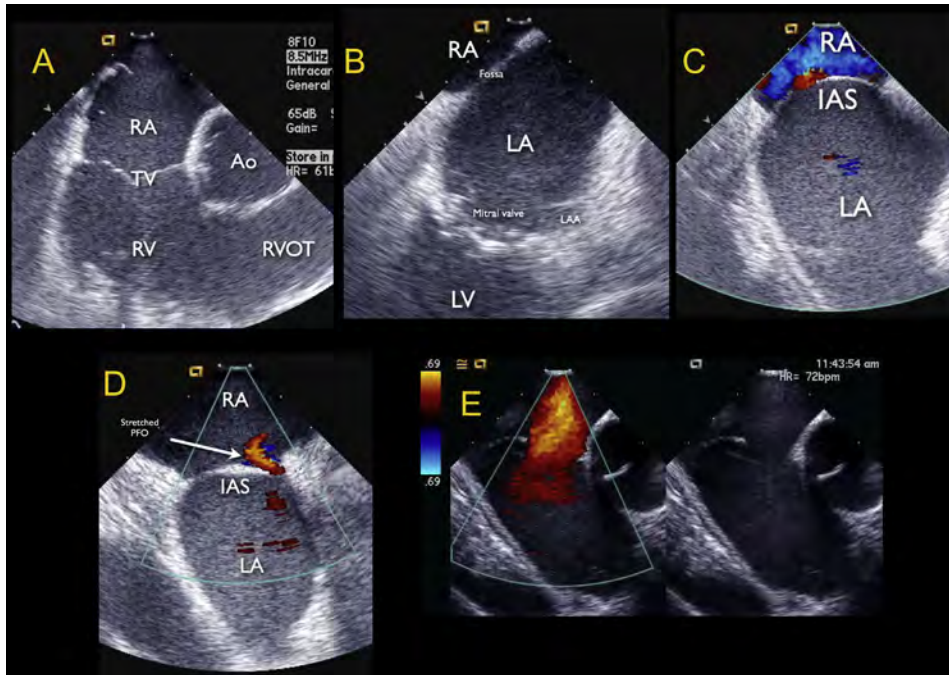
Intracardiac echocardiographic evaluation of the IAS (see the section on Intracardiac Echocardiographic Imaging Protocol for IAS for details). (A) Home view. (B) Septal long-axis view. (C) Bicaval view. (D) Septal short-axis view of PFO. (E) Septal short-axis view of ostium secundum ASD. The *white arrow* indicates the direction of PFO flow through stretched PFO. LAA, left atrial appendage; RVOT, right ventricular outflow tract; TV, tricuspid valve. See also [Video 19](#).
